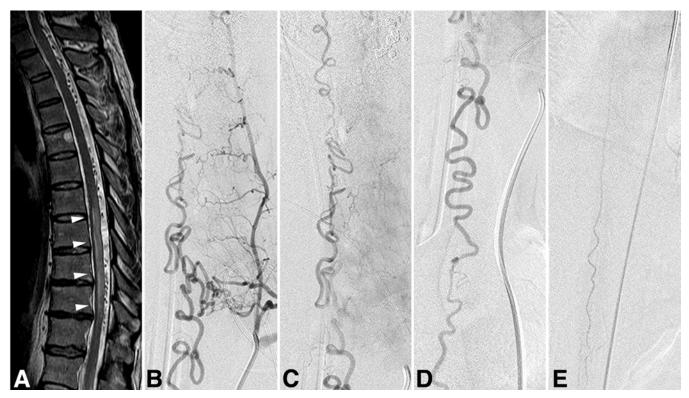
Case 1. Sagittal T2-weighted MR image (A) demonstrating an intramedullary hyperintensity between T-7 and T-11 (arrowheads), as well as serpentine perimedullary hypointensity signals. Anteroposterior angiograms (B, early phase; C and D, late phase) of the left T-1 segmental artery revealing a shunt fed by the T-1 radiculomeningeal artery (B), draining via a radicular vein into ascending perimedullary veins up to the upper cervical level (C) and descending perimedullary veins down to the thoracolumbar level (D). Stasis of contrast material in the affected perimedullary veins is noticed in the late venous phase (C and D). Anteroposterior angiogram (E) obtained in the late venous phase of the left T-8 segmental artery, demonstrating stasis of contrast material in the anterior spinal artery at the thoracolumbar level, indicating venous congestion of the spinal cord.
